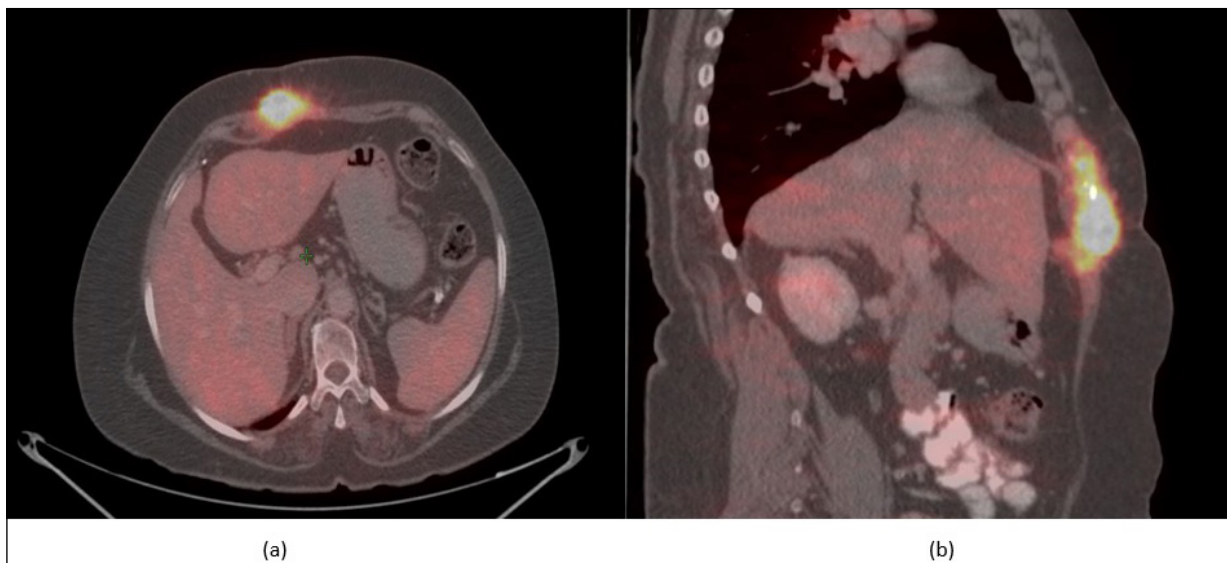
Sections of PET CT scan of the patient showing epigastric nodule (a) axial view and (b) sagittal view.
